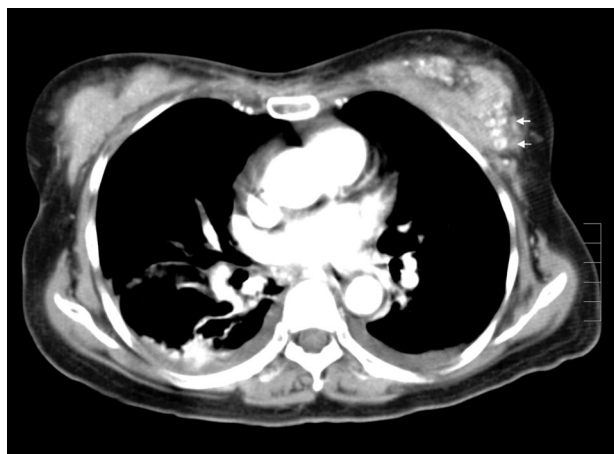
Computed tomographic scan of a 63-year-old woman following silicone injection demonstrates multiple calcified nodules in the left breast (small white arrows; above, right).
